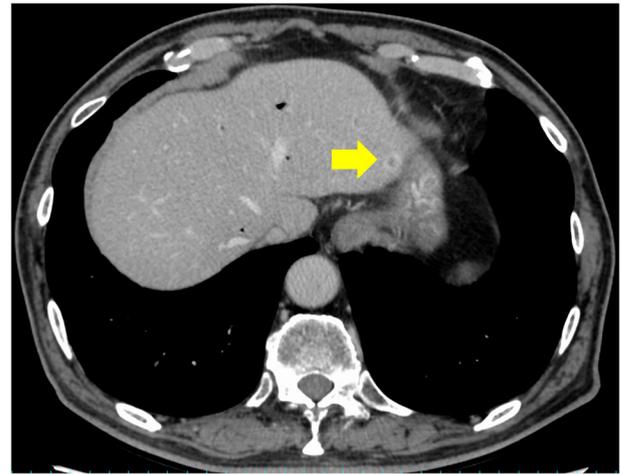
Image findings of the contrast-enhanced dynamic-computed tomography performed after NAC. Image shows an 8-mm ring-enhanced nodule in liver segment S3 (yellow arrow).
